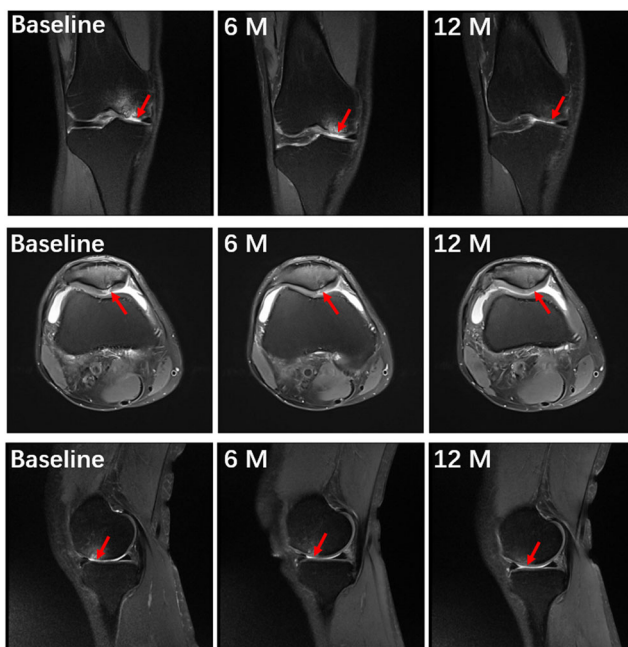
Magnetic resonance imaging scans of three SVF-treated knees from baseline to 6 and 12-months follow-up showed complete repair and filling of the defects, as well as good integration with the adjacent cartilage and underlying bone in the coronal, transverse and sagittal planes (red arrows)
